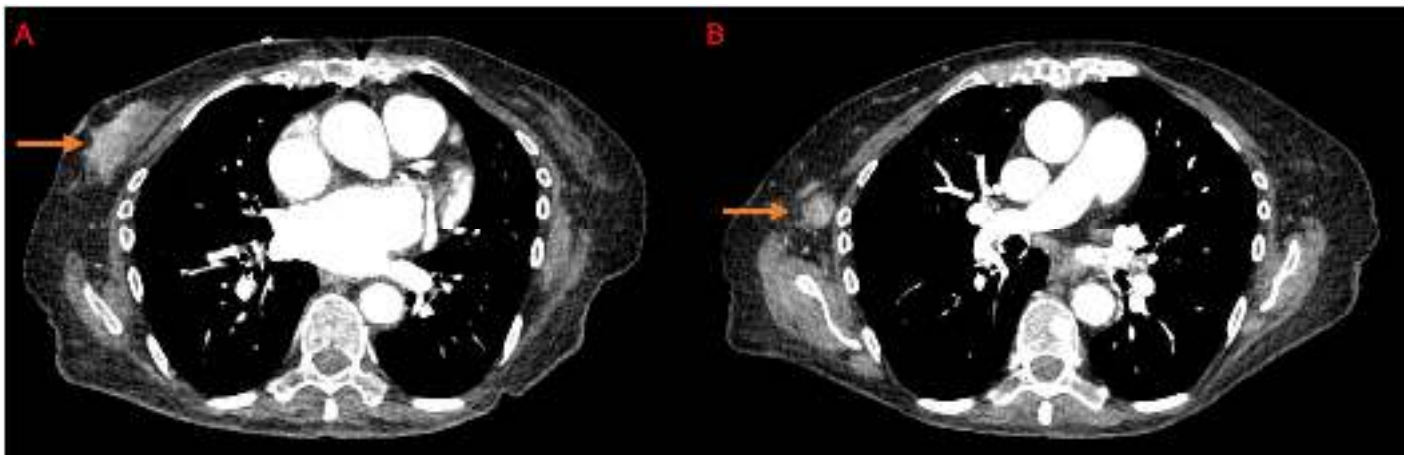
Coronary CT scan shows right breast mass (A) with axillary lymphadenopathy (B).
